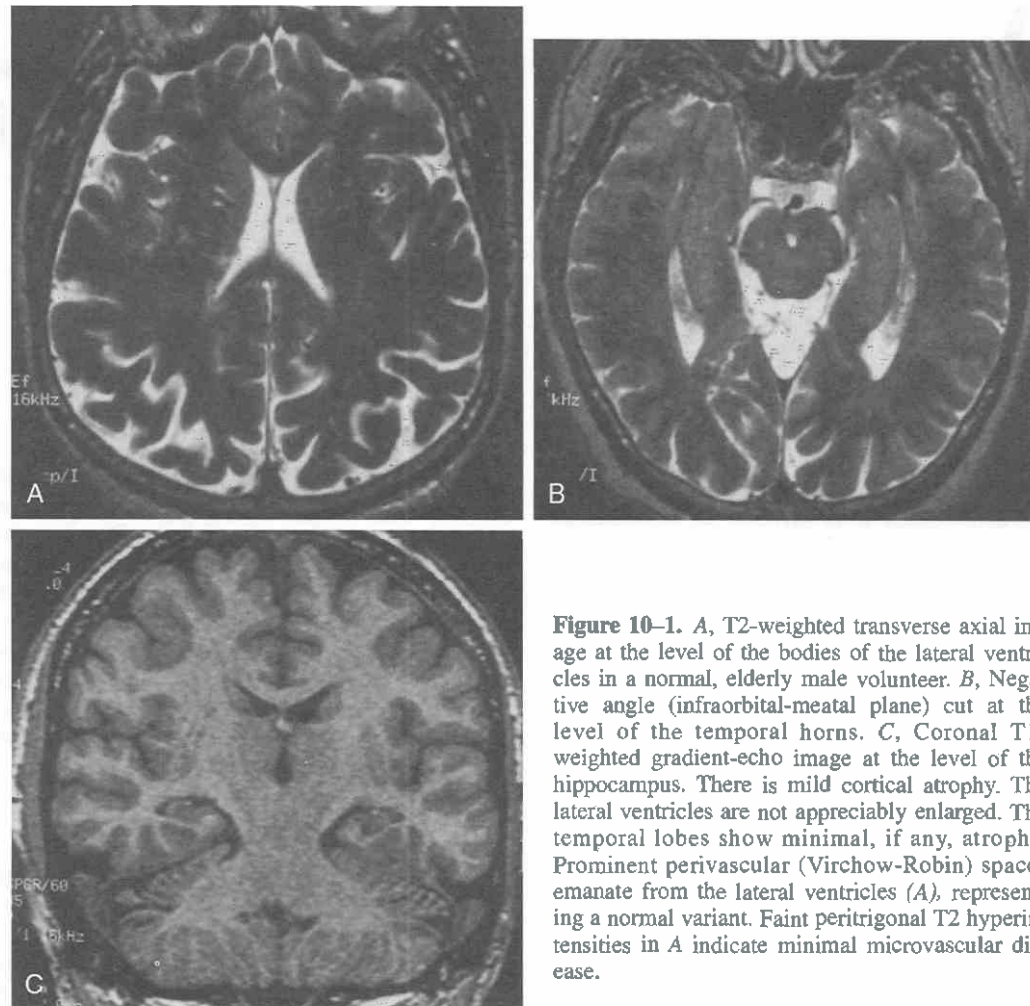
A, T2-weighted transverse axial image at the level of the bodies of the lateral ventricles in a normal, elderly male volunteer. B, Negative angle (infraorbital-meatal plane) cut at the level of the temporal horns. C, Coronal T1-weighted gradient-echo image at the level of the hippocampus. There is mild cortical atrophy. The lateral ventricles are not appreciably enlarged. The temporal lobes show minimal, if any, atrophy. Prominent perivascular (Virchow-Robin) spaces emanate from the lateral ventricles (A), representing a normal variant. Faint peritrigonal T2 hyperintensities in A indicate minimal microvascular disease.
